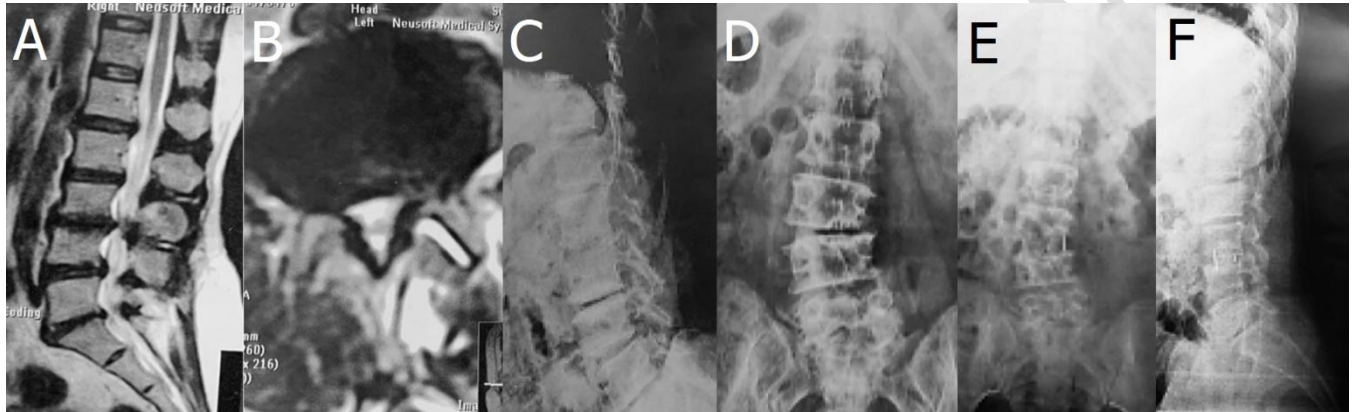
Case 2 A. MRI pre-operative T2W Axial cuts showing facet effusion and disc prolapse, B. MRI pre-operative T2W sagittal cuts showing canal stenosis at L3/L4 and decreased disc height. C: pre-operative lateral lumbar X-ray showing degenerated intervertebral disc L3/L4, *SVA*: 10 mm, *PT*: 27 degrees, *SS*: 33 degrees, *LL*: 18 degrees, *PI/LL mismatch*: 38 and *anterior disc height*: 5 mm. D: pre-operative AP lumbar X-ray shows *Cobb angle* of 28 degrees, E: demonstrates AP lumbar X-ray 1-year follow up with corrected *Cobb angle* to 7.3 degrees after stand-alone OLIF L3/L4 and F: demonstrates lateral lumbar X-ray 1-year follow up; *SVA*: 6 mm, *SS*: 35 degrees, *PT*: 25 degrees, *LL* 22 degrees, *anterior disc height*: 14 mm and *PI/LL mismatch*: 35.
